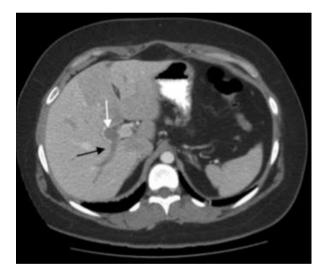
Contrastmedium-enhanced axial computed tomography of the abdomen shows splenic vein thrombus after LSG
